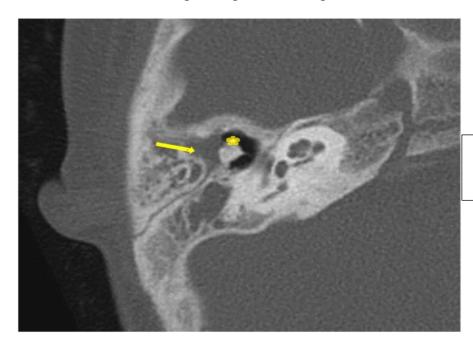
showing HRCT depicting cholesteatoma.
